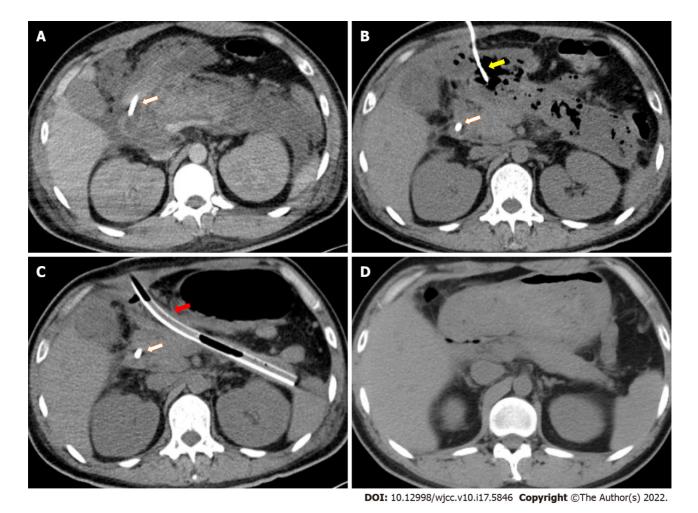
Pancreatic imaging changes during the course of disease. The jejunal feeding tube is marked by a white arrow. The percutaneous drainage tube for the pancreatic head region is marked by a yellow arrow. A: Contrast-enhanced computed tomography (CT) demonstrating pancreatic edema and profound peripancreatic exudation after severe acute pancreatitis (SAP) onset; B: CT demonstrating peripancreatic infected necrosis 2 mo after SAP onset; C: CT after nephroscopy-assisted debridement of peripancreatic necrosis 3 mo after SAP onset. One of the thicker drainage tubes is marked by a red arrow; D: CT demonstrating recovery 10 mo after SAP onset.
